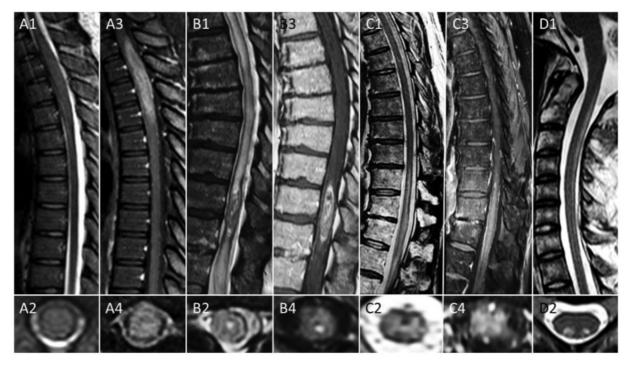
Examples of other intrinsic causes of myelopathy. (A) High-grade spinal cord astrocytoma. A longitudinally extensive iso- to hyperintense lesion is evident in the upper thoracic spinal cord on T2-weighted images (A1–A2). Diffuse, nonspecific lesion enhancement is noted after gadolinium (A3–A4). (B) Spinal cord intramedullary metastasis. A highly heterogeneous T2-lesion is evident in the lower thoracic spinal cord (B1), with irregular, mostly peripheral enhancement after gadolinium (B3). A focal dotty area of hyperintense signal in the center of the spinal cord is evident on both T2-weighted (B2) and postgadolinium T1-weighted (B4) sequences axially ("central dot sign"). (C) West Nile virus myelitis. A longitudinally extensive T2-hyperintense lesion, predominantly affecting the central gray matter, is evident in the lower third of the thoracic spinal cord (C1–C2). Diffuse, nonspecific enhancement is noted after gadolinium in the affected spinal cord parenchyma and adjacent leptomeninges (C3–C4). (D) Myelopathy from intrathecal methotrexate infusion. A longitudinally extensive T2-hyperintensity is evident along the dorsal columns in the cervical and upper thoracic spinal cord on both sagittal (D1) and axial (D2) images. The lesion does not enhance after gadolinium (not shown).
